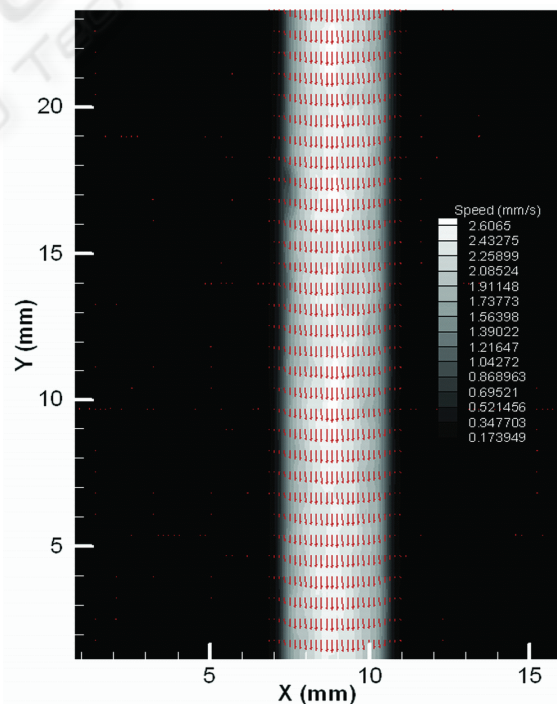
Mean velocity field of glycerin flow in a tube measured by the compact X-ray PIV system.
